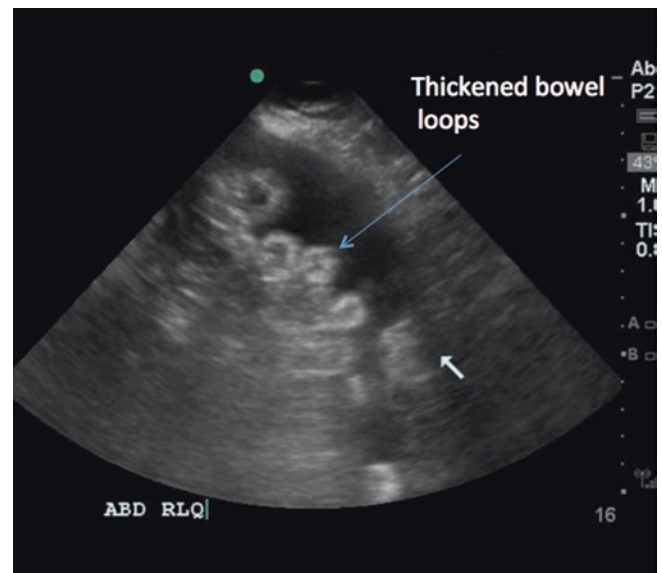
Abdominal ultrasound in a patient with ascites. This image shows ascites with markedly thickened bowel loops due to gastroenteritis. Please compare to Fig. 37.17, in which normal appearing bowel loops are seen. See also Video 37.19
